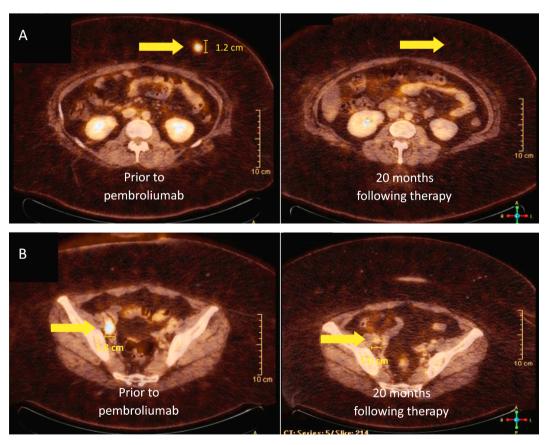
(A) Pre-ICI PET-CT (left) shows metastasis to anterior abdominal wall 1.2×1.0 cm with SUV 6.4, with disappearance of this lesion on 20 month post-treatment scan (right); (B) Pre-ICI PET CT shows right external iliac lymph node with prominent hypermetabolism, 1.8×2.0 cm with SUV 12.5; 20 month post-treatment (right) shows decrease to 1.0×1.1 cm with SUV 3.1.
